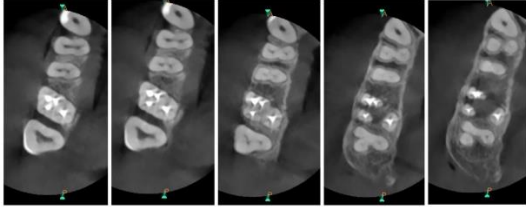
Consecutive post operative CB-CT imaging-axial view, confirming 2 confluent canals.
